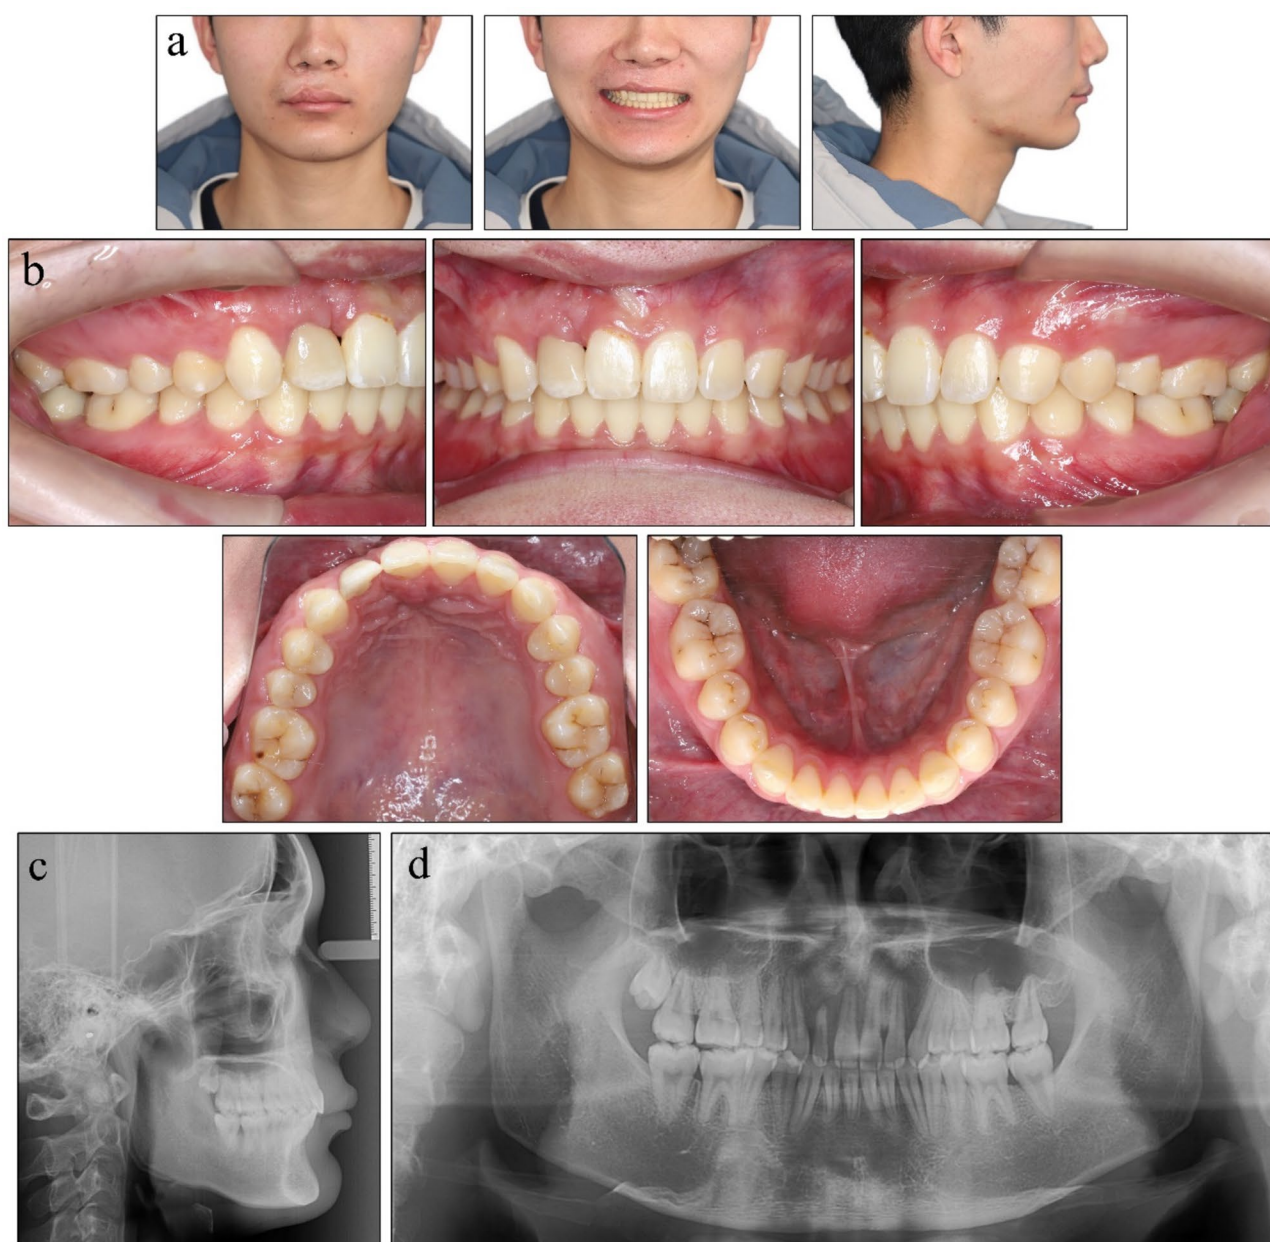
Posttreatment examinations of this patient. (a) Posttreatment facial photographs. (b) Posttreatment intraoral photographs. (c) Posttreatment lateral cephalogram. (d) Posttreatment panoramic radiograph
